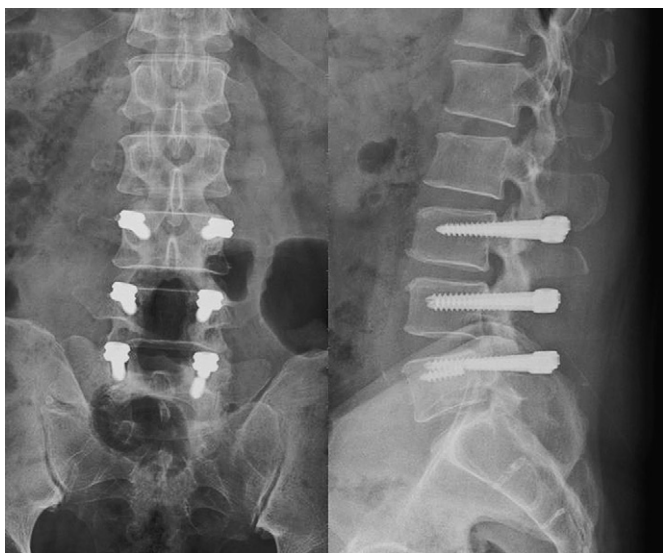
The patient complained of progressive intractable low back pain 7 months after surgery. Repeat radiography revealed loosening of the right L5 pedicle screw and breakage of the left L5 pedicle screw.
